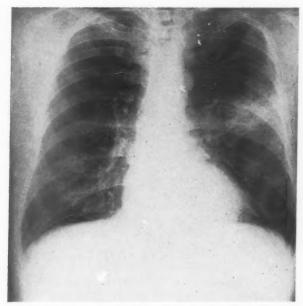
A fifty-six year old white man with pain in the left side of the chest of several months' duration, mild temperature elevation and blood streaked sputum. Unilateral wheeze was audible over the lower lobe of the left lung. X-ray films disclosed a mass in the left midlung field.
